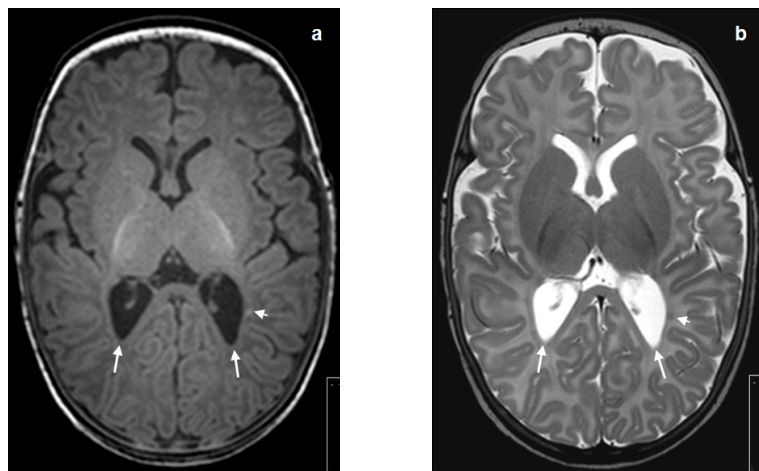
Transverse T_1 - (a) and T_2 -weighted (b) MRI of preterm infant (gestational age 26.9 weeks), scanned at postmenstrual age 42.7 weeks, showing bilateral, multiple punctate white matter lesions (short arrows). Also showing dilated, irregularly shaped lateral ventricles and widening of extracerebral spaces. T_2 additionally shows diffuse and excessive high signal intensity in occipital white matter (long arrows) (MRI white matter score: moderately abnormal).
